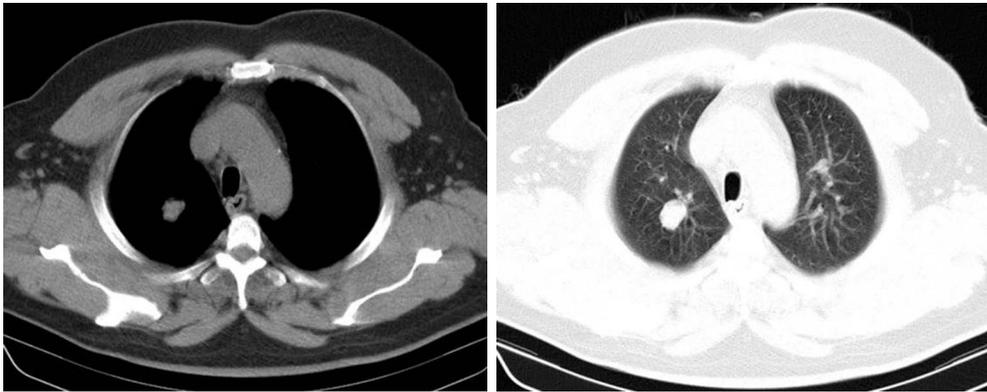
A 25×20 mm hypodense nodule with an oval shape and smooth margins is observed to be localized in the right upper lobe in the axial sections of thorax computed tomography scan performed in 2010.
